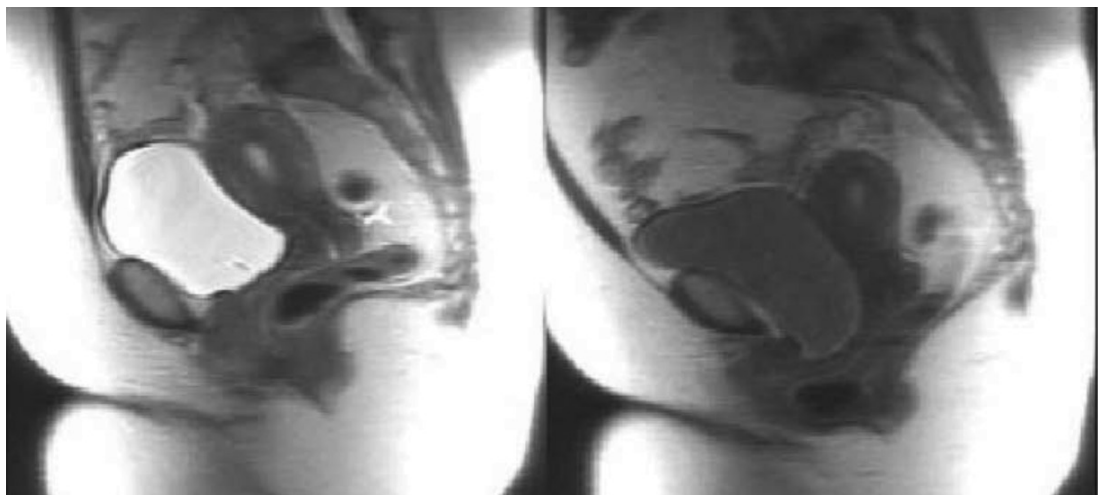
Figure B 40: Pelvic floor MRI: grade 2 (a) and grade 3 (b) cystocele
